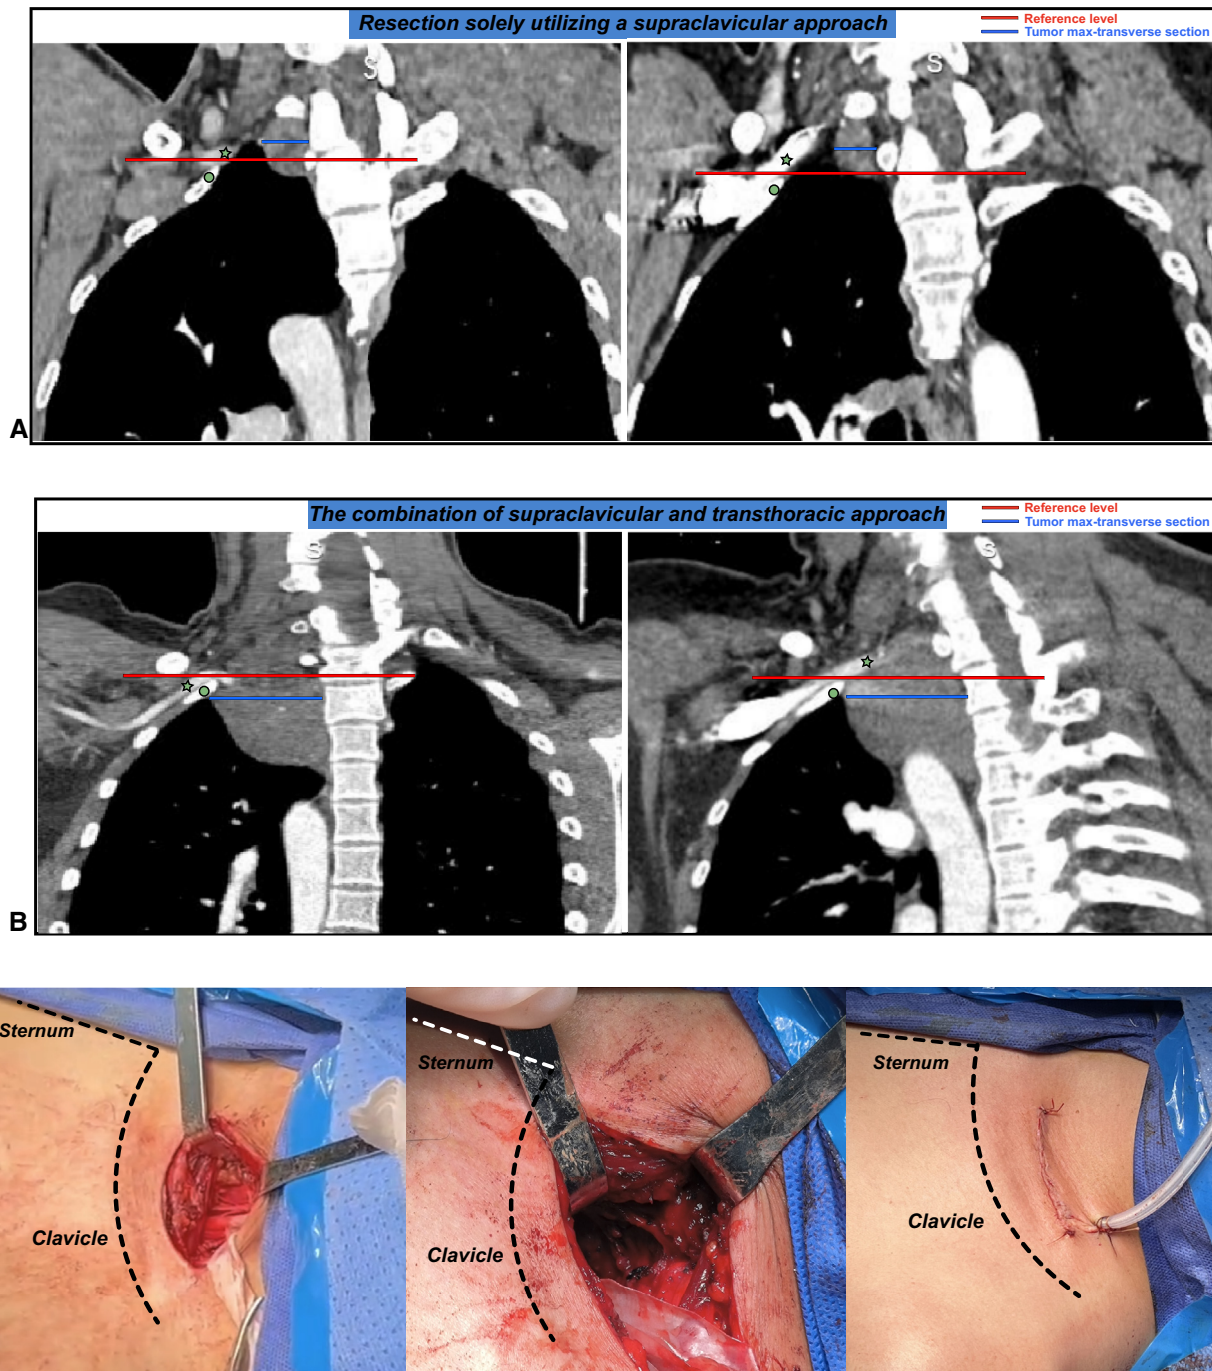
Examples of patients underwent resection using supraclavicular approach solely (A) or combined with transthoracic approach (B), and the intraoperative photograph demonstrating the access to thoracic apex from the supraclavicular incision (C); *pentagram*: subclavian artery; *dot*: first rib; *red line*: reference level; *blue line*: max-transverse section of tumor.
